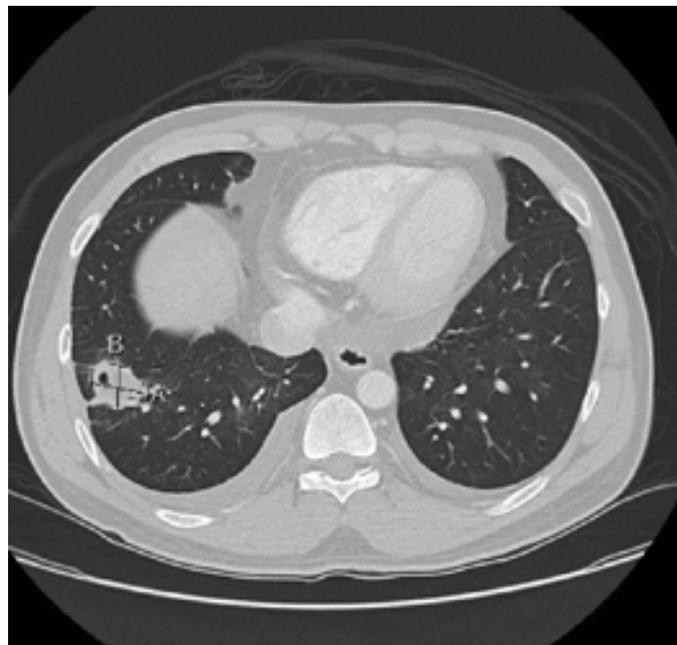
Chest computed tomography scan revealing a 2.9 × 2.3 cm pulmonary abscess in the right lower lobe.
